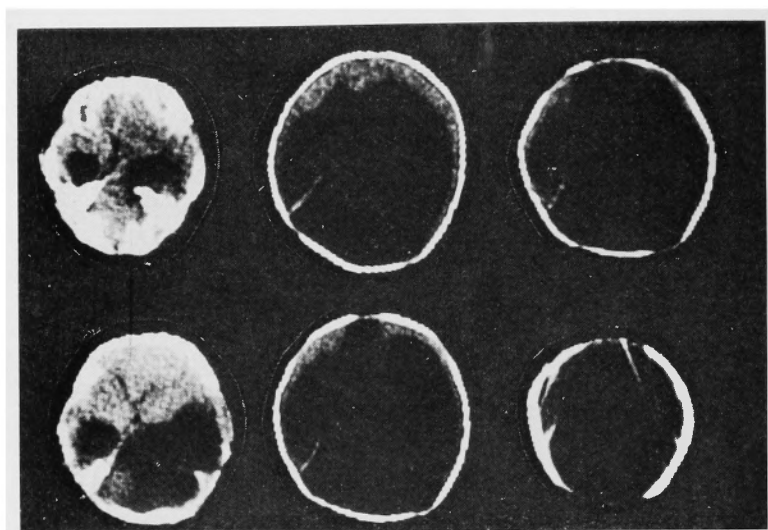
Case 2. CT scan showing a large monoventricle with thin peripheral rim of cortex. No falx was seen, but there was a thin band extending from left pyramis up to parietal region.
